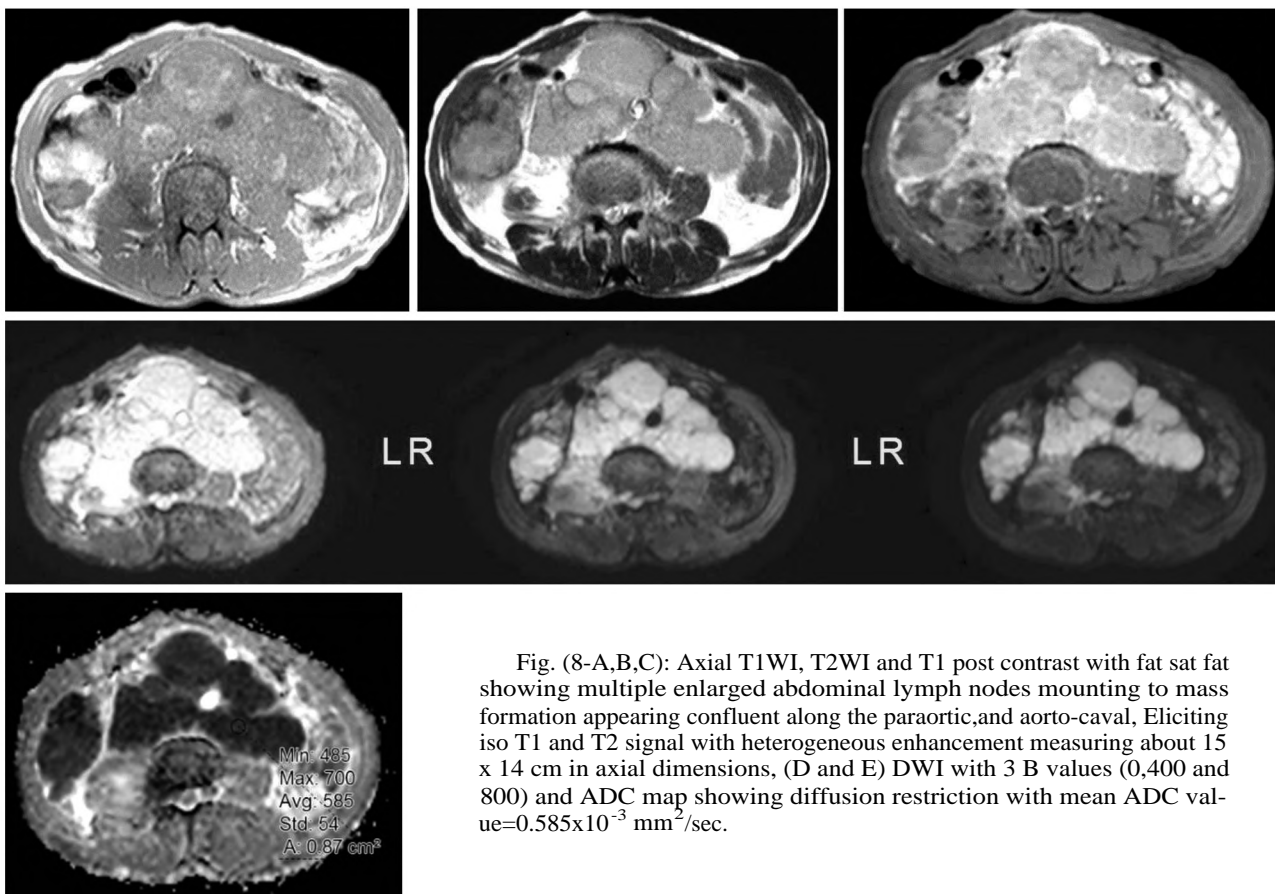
Axial T1WI, T2WI and T1 post contrast with fat sat fat showing multiple enlarged abdominal lymph nodes mounting to mass formation appearing confluent along the paraortic, and aorto-caval. Eliciting iso T1 and T2 signal with heterogeneous enhancement measuring about 15 x 14 cm in axial dimensions, (D and E) DWI with 3 B values (0,400 and 800) and ADC map showing diffusion restriction with mean ADC value= $0.585 \times 10^{-3} \text{ mm}^2/\text{sec}$.
